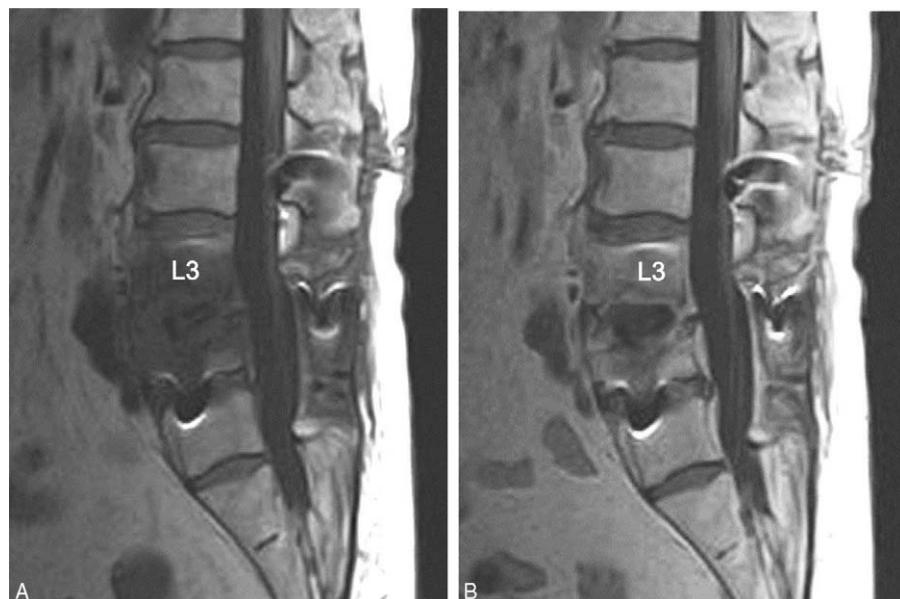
Magnetic resonance imaging of the lumbar spine before a second revision surgery. A, Sagittal T1-weighted image. Decreased signal intensity at the L3-4 disc space and adjacent vertebral bodies was noted. B, Contrast-enhanced sagittal T1-weighted image. Enhancement of the L3-4 disc space around cages and L3 and L4 vertebrae was noted.
